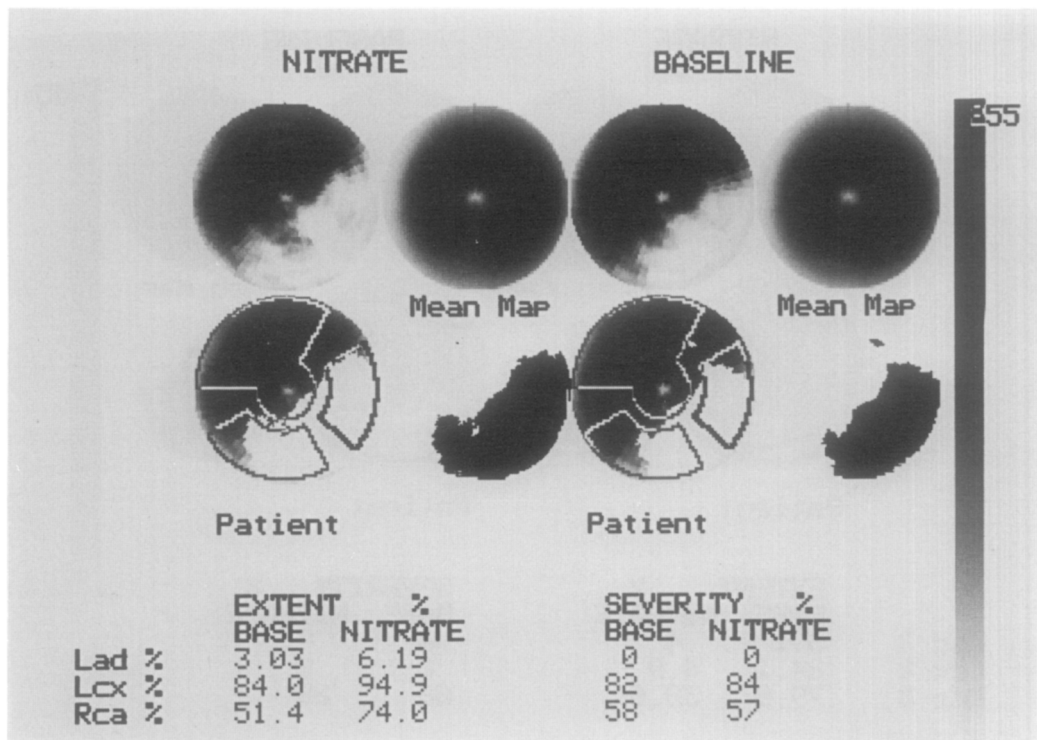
Polar map displays of patient with three-vessel disease who had inferior and inferolateral akinesis in preoperative echocardiogram. Image disposition and abbreviations are same as in Figure 3. Analysis of defect severity in both baseline and nitrate SPECT indicated that left circumflex and right coronary artery territories were not viable. After triple bypass grafting, patient showed improvement in anginal symptoms but no functional recovery in either territory.
